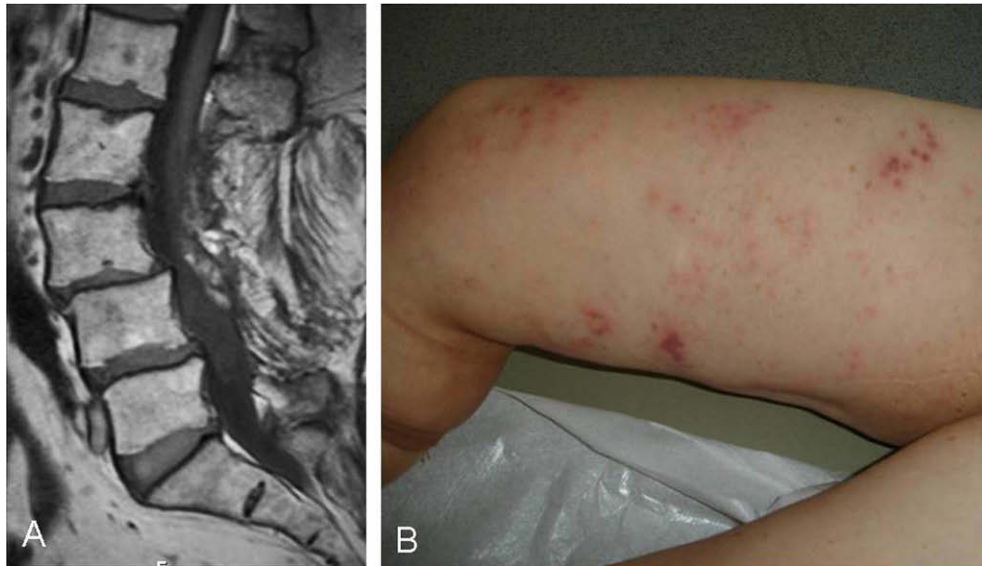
(A) Sagittal T1-weighted lumbar MRI showing degenerative changes. (B) Skin lesions along the trajectories of the L3 and L4 nerve roots.
